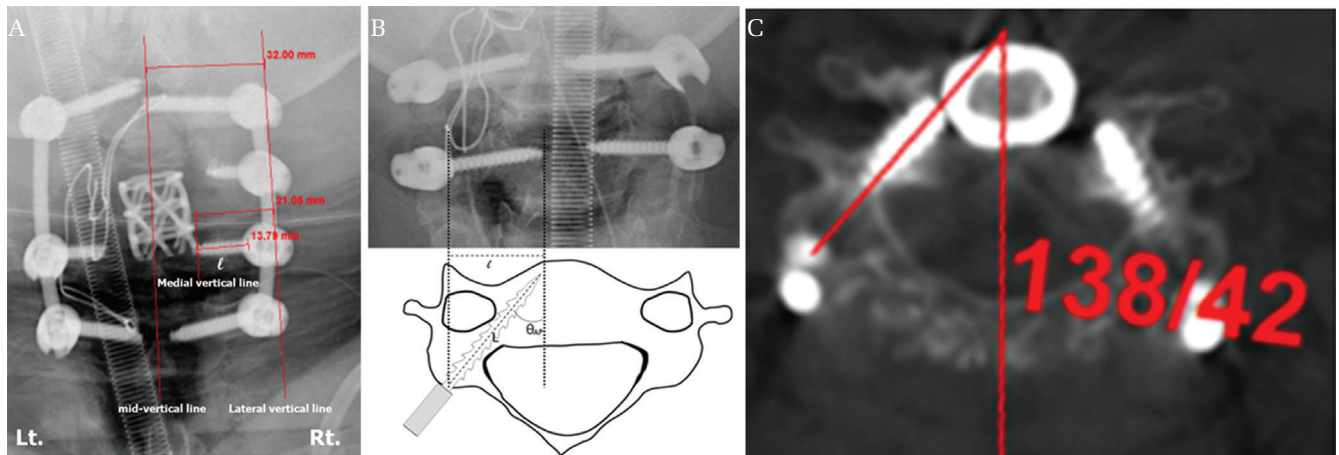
(A) Intraoperative AP X-ray of 66-year-old female patient with infective spondylitis on C4-5 level. Because of the anterior cage, the use of a longer screw seems to be impossible during CPS on the C3-4-5-6 level. The length of the screw used was 20 mm on the right C5 level. If we apply the previous AP X-ray interpretation method on the right C5 screw (i.e., the screw tip should be medial to a point located laterally to the midline by an amount of one-quarter of the distance from the midline to the lateral border of the lateral mass on AP X-ray), this screw should be regarded as out of pedicle (i.e., $21.05/32 = 0.66 < 0.75$). This misinterpretation led us to develop another widely applicable method. After magnifying the AP image 2.5 times in the PACS to perform the delicate measurement, a mid-vertical line is drawn using the information of spinous and uncinete process location. Then, a lateral vertical line connecting the lateral border of lateral masses is also drawn, parallel to the mid-vertical line. We also draw another medial vertical line crossing the screw tip, and parallel to the mid-vertical and lateral vertical lines. The CPS body length of I is measured from the medial vertical line to the base of the screw shaft. Mid-point on the most highly dense area, which is intersected between the screw head and the base of the screw shaft, is used and regarded as the lateral end of I . (B) Horizontal distance of the CPS body (I) as shown by intraoperative AP X-ray. If the actual length of a screw (L) is known, the medial angle (θ_{AP}) can be calculated using the inverse value of the sine function, $\theta_{AP} = \sin^{-1} I / L$. (C) The postoperative axial CT scan of the same patient of Figure 2-A on the C5 level shows an accurate position of CPS, and θ_{ins} of the right side screw is 42 degrees. If we calculate θ_{AP} from Figure 2-A, $\theta_{AP} = \sin^{-1} I / L = \sin^{-1} (13.79/20) = 43.5$. Because this θ_{AP} was much bigger than θ_{med} (34°), we regarded this screw as safe during the operation and identified nearly the same value with θ_{ins} (42°) after surgery.
